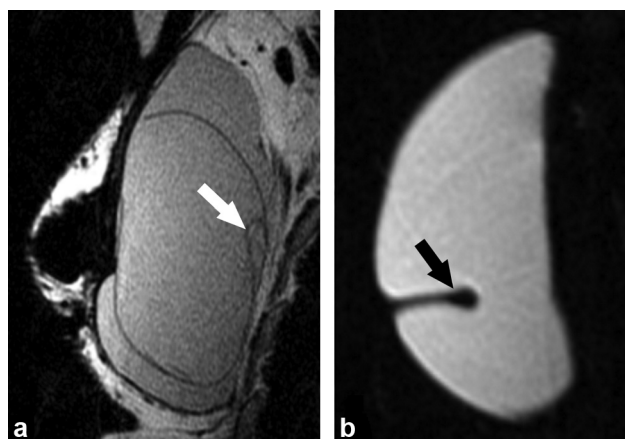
MR images obtained in two different women with breast implants. (a) A 65-year-old woman with history of right breast cancer following mastectomy and implant placement. T2-weighted MR image obtained in the sagittal plane demonstrates the linguine sign associated with intracapsular implant rupture (arrow); (b) a 74-year-old woman with a history of breast cancer following mastectomy and breast implant placement. Silicone specific MR image obtained in the sagittal plane demonstrates a radial fold (arrow) without implant rupture.
